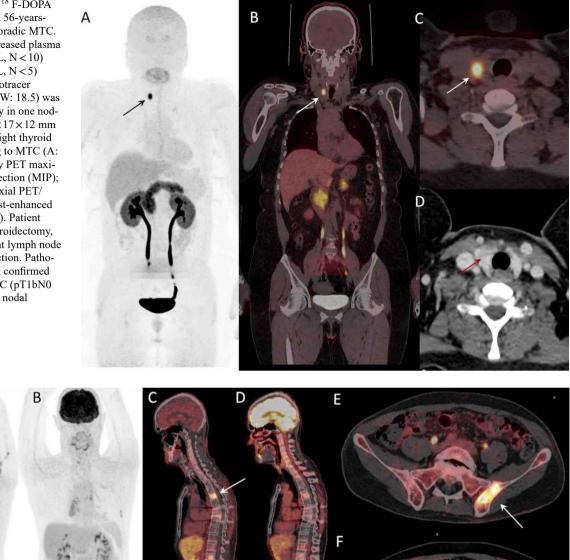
A 48-years-old man with metastatic MTC and previous history of thyroidectomy and central and right lymph node compartment dissection, presenting with increased serum calcitonin level (193 ng/L, N < 10) and almost normal CEA. Patient underwent ¹⁸ F-FDOPA PET/CT (arrows, A: anterior maximum intensity projection (MIP);
